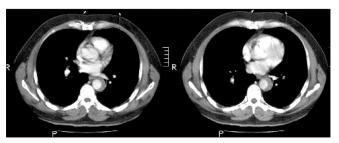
CT of the chest in a 59-year-old man with a type B aortic dissection.
